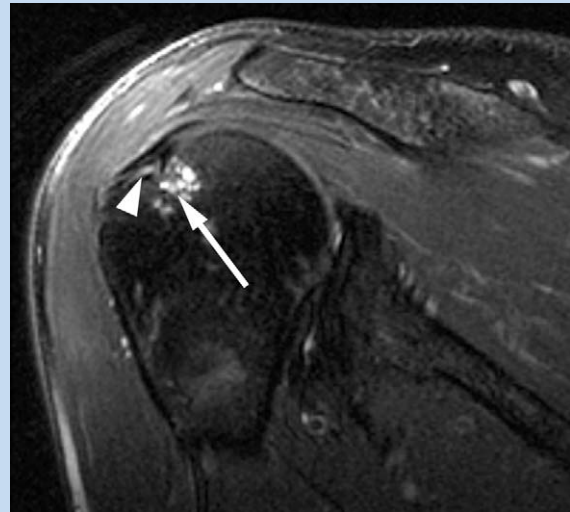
A fat-suppressed T2-weighted image in a professional baseball player with clinical signs of internal impingement reveals prominent cystic changes within the posterior greater tuberosity (arrow). Subtle articular surface partial tearing is seen at the anterior infraspinatus insertion (arrowhead). No labral tear was found in this patient.
